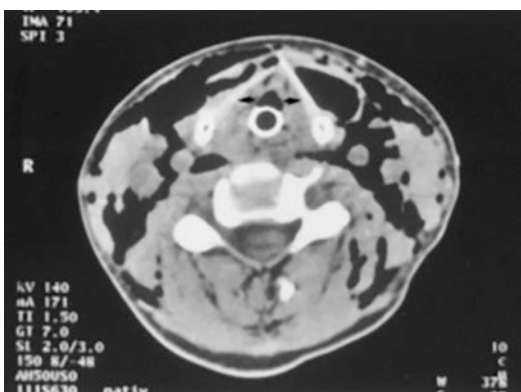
CT image of a patient with median fracture of the thyroid cartilage. There is extensive subcutaneous emphysema in the neck suggesting soft tissue injury to the larynx. There is an endotracheal tube in the larynx
